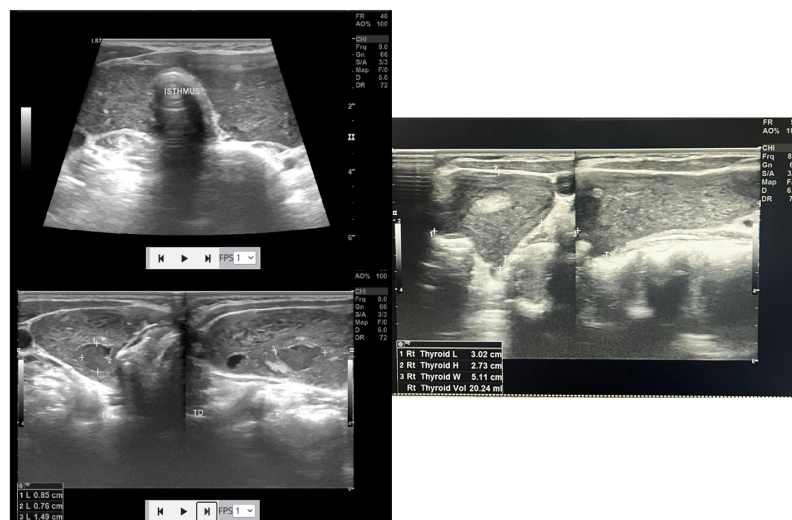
Thyroid Ultrasound. The image shows a bilateral nodular goiter (TI-RADS 3) with calcification in the left thyroid lobe. The parenchyma has a heterogeneous echotexture, suggestive of thyroiditis.
